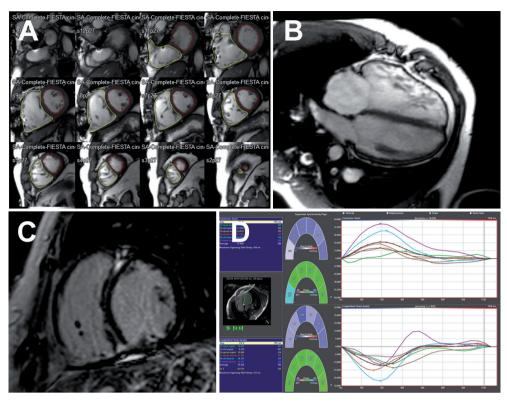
Cardiac magnetic resonance imaging parameters that are reported to be of prognostic importance in patients with ACHD.
